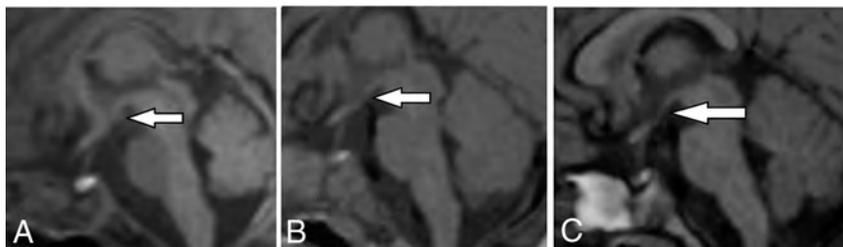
Sagittal T1-weighted MR imaging. The arrows indicate abnormal, low signal in MBs at 6 days (A) and MB atrophy at 3 (B) and 19 (C) months.
